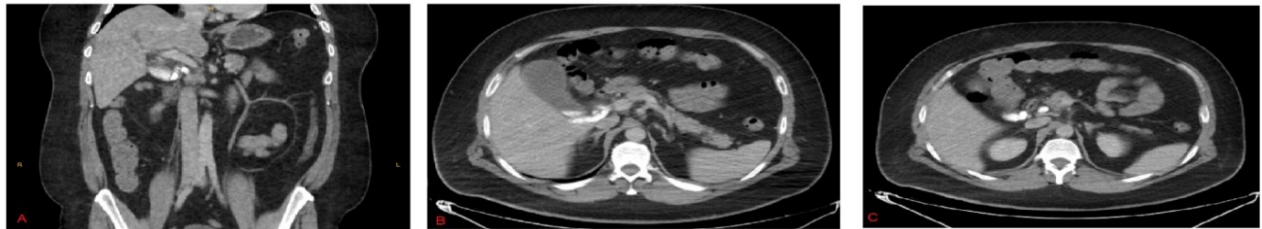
Gallbladder, intrahepatic/extrahepatic biliary tract and pancreatic ducts filled with radiopaque “contrast” like hydatid cyst contents, mimicking “contrast enhanced cholangiography” – Preoperative CT scan
